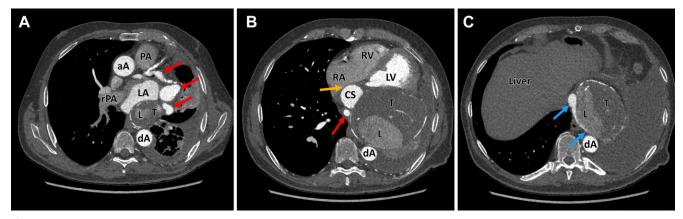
Axial cardiac CT angiographic images demonstrate the presence of a dilated left circumflex coronary artery with fistula to a dilated coronary sinus (CS) with ostial atresia and aneurysm. (A) Dilated and tortuous left circumflex coronary artery (red arrows). (B) Dilated, opacified CS adjacent to the right atrium (RA) without communication, demonstrating an ostial atresia (yellow arrow). A large, partially thrombosed aneurysm is visualized with a patent lumen. Red arrow indicates left circumflex coronary artery. (C) Drainage of the CS (blue arrows) into lumen of a large, partially calcified, partially thrombosed aneurysm. See Movie 1 for axial, sagittal, and coronal cuts, and see Movie 2 for three-dimensional reconstruction. aA = ascending aorta, dA = descending aorta, L = lumen of aneurysm, LA = left atrium, LV = left ventricle, PA = pulmonary artery, rPA = right PA, RV = right ventricle, T = thrombus of aneurysm.
